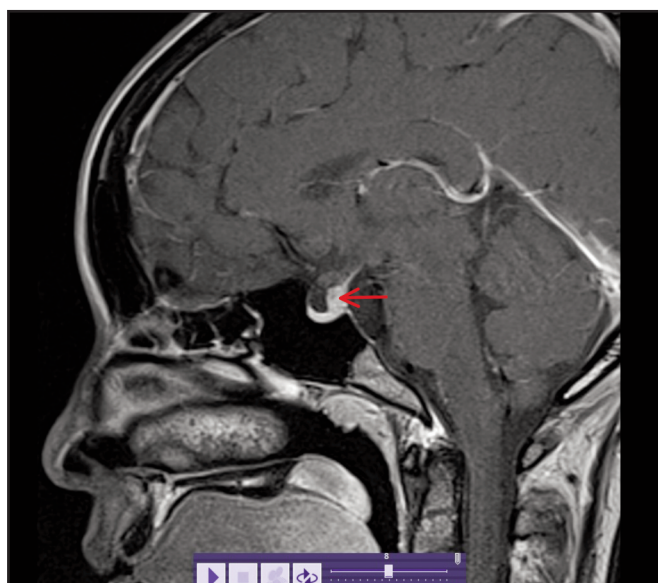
Contrast-enhanced sagittal T1-weighted MRI image of the pituitary demonstrating thickening of the pituitary stalk (red arrow). The pituitary gland and optic chiasm appear normal.
